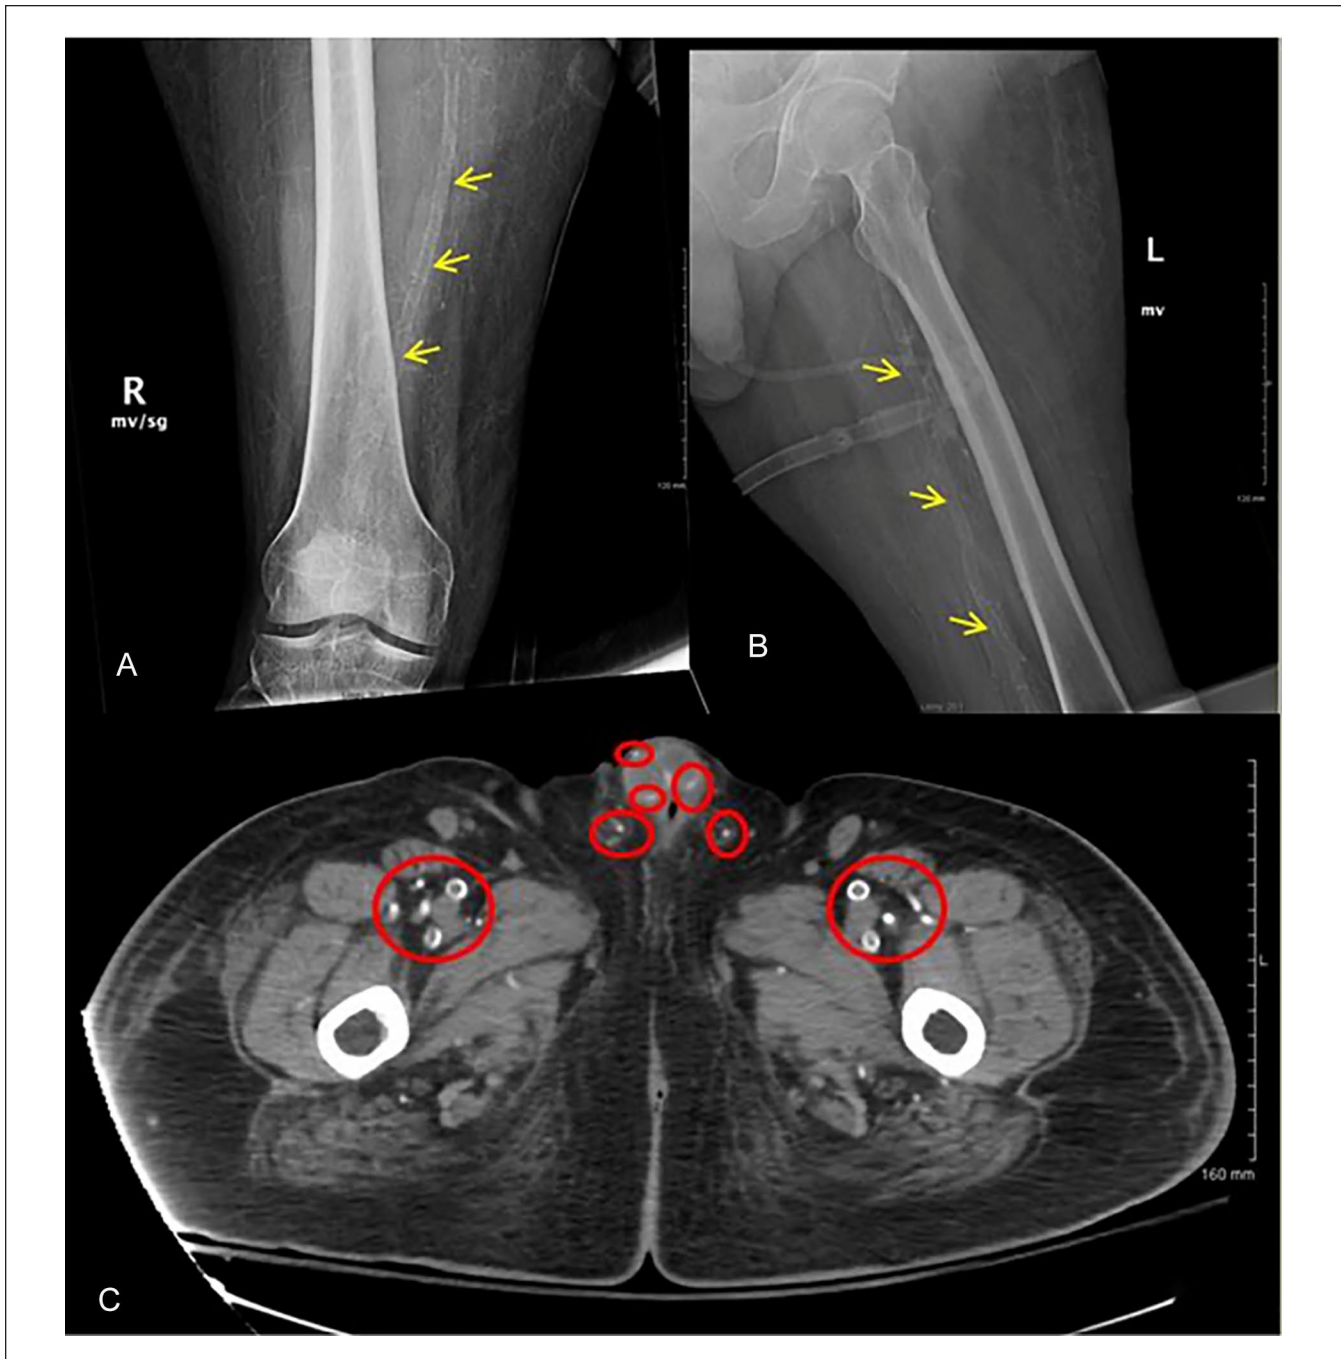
(A) Right distal femur plain radiograph showing medial calcification of right femoral artery (arrows). Subtle subcutaneous calcifications can be appreciated. (B) Left proximal femur plain radiograph showing medial calcification of left femoral artery (arrows). Subtle subcutaneous calcifications can be appreciated. (C) Axial view of pelvic computed tomographic scan without intravenous contrast showing medial artery calcification of femoral arteries as well as penile arteries.
